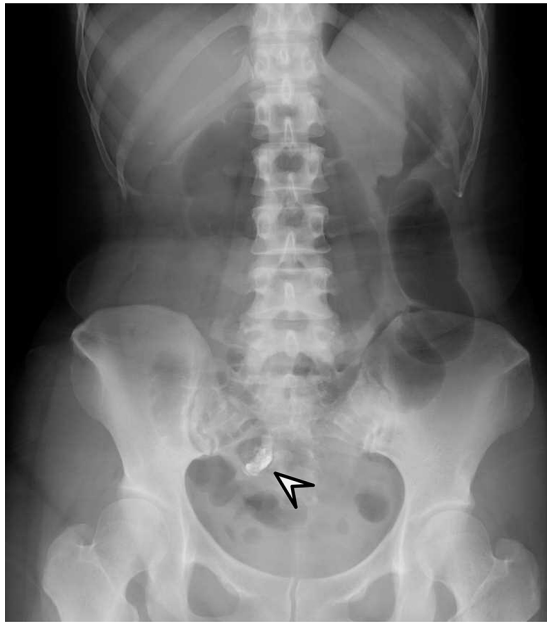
Radiograph examination. Radiopaque objects in the middle lower abdomen (arrowhead).
